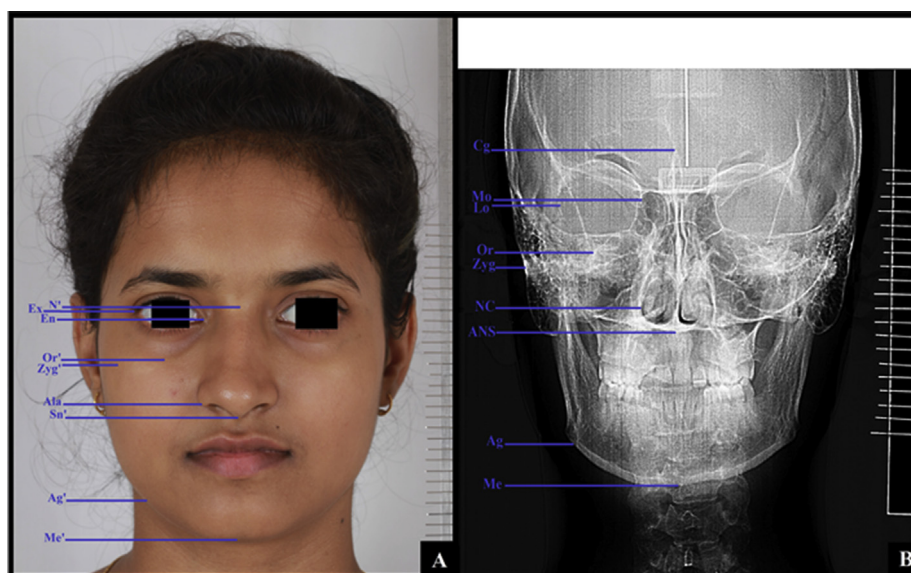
(a) The soft tissue landmarks. (b) Radiographic landmarks.
